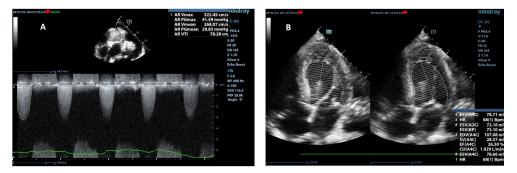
b.7. Low-flow low-gradient pattern of severe aortic stenosis (MPG=29 mmHg; AVA=0.47 cm<sup>2</sup>, SV=28 ml; LVEF=26%; A: 5-chambers view CW Doppler; B:4-chambers view 2D)
